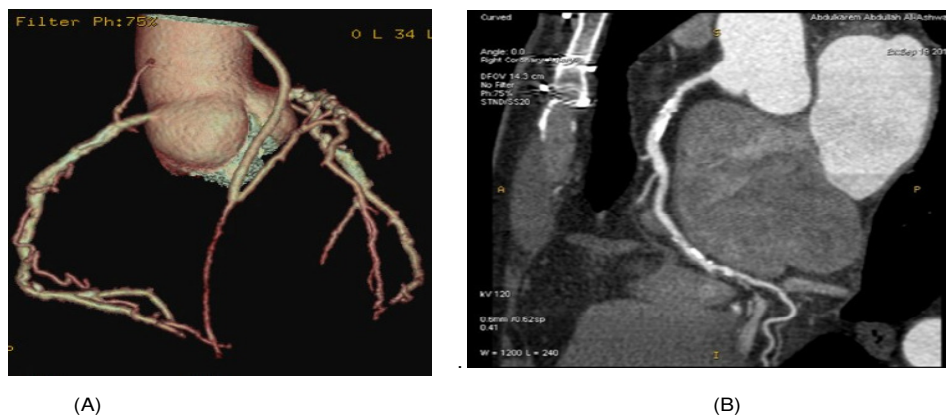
Shows Coronary CT angiography with (A) 3D volume rendering image, and (B) curved multiplanar reformatted, (MPR) of CAC score is 843.grafting of the LAD with LIMA with 3 vessel disease. Subtotal stenosis in the proximal part of the left circumflex artery.
